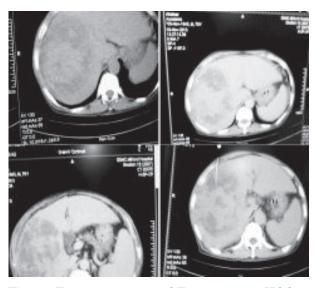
Triple phase axial CT scan shows HCC in right lobe of liver with irregular margin Lesion is inhomogenously hypodense in NECT, inhomogenously hyperdense on postcontrast arterial phase, wash out of contrast seen in venous phase. CT guided Fine needle aspiration biopsy done on the same patient.
